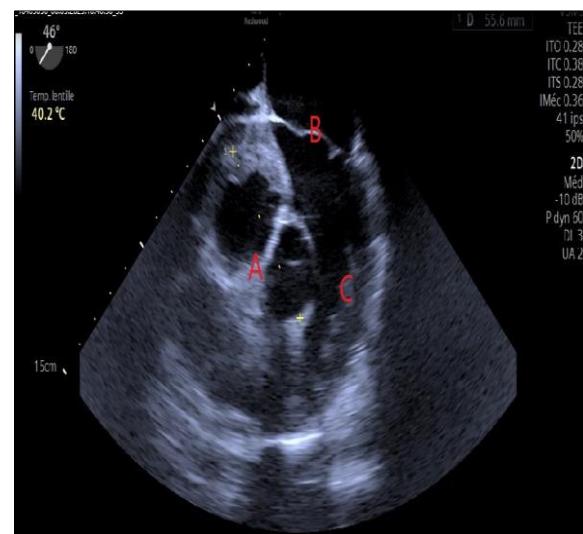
Transesophageal Doppler echocardiography performed at the mid-esophageal level, apical four-chamber view at a 40.2° angle (A = septal abscess cavity; B = mitral valve; C = left ventricle)
